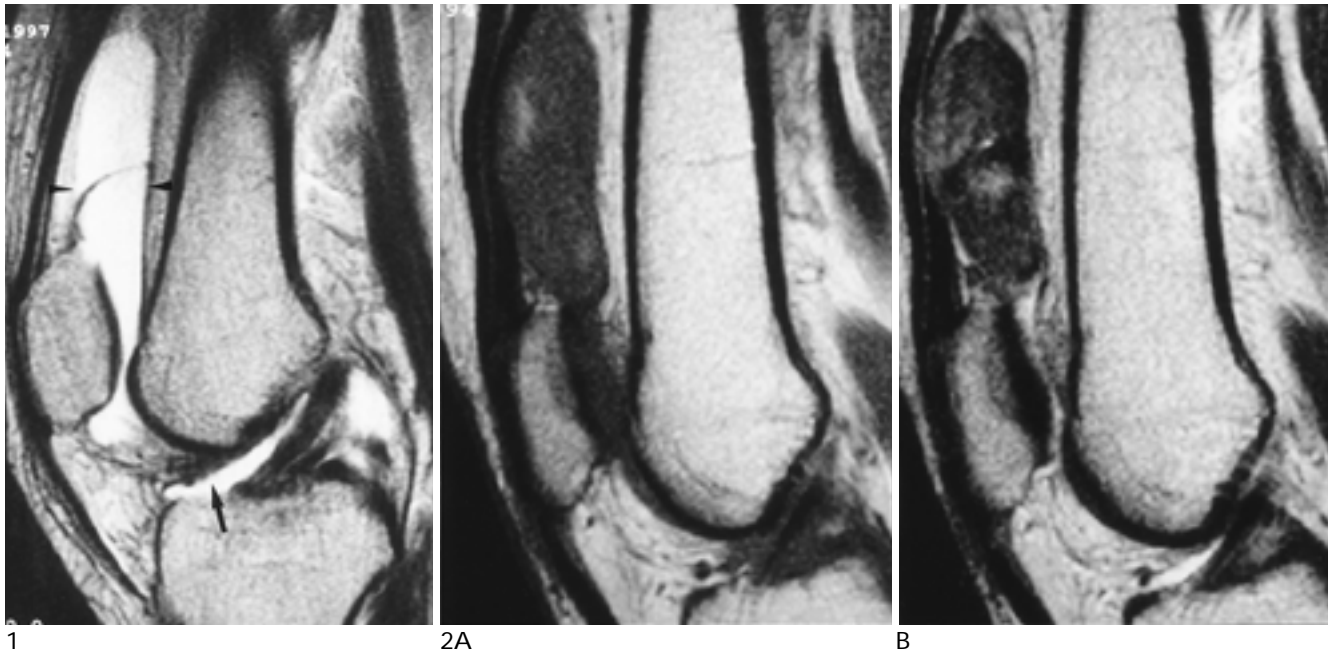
Lateral tibial condyle fracture with joint effusion in a 35-year-old man. Sagittal T2-weighted MRI shows a large amount of effusion (between arrowheads) in the suprapatellar pouch, and a para-ACL effusion in the central portion (arrow).
